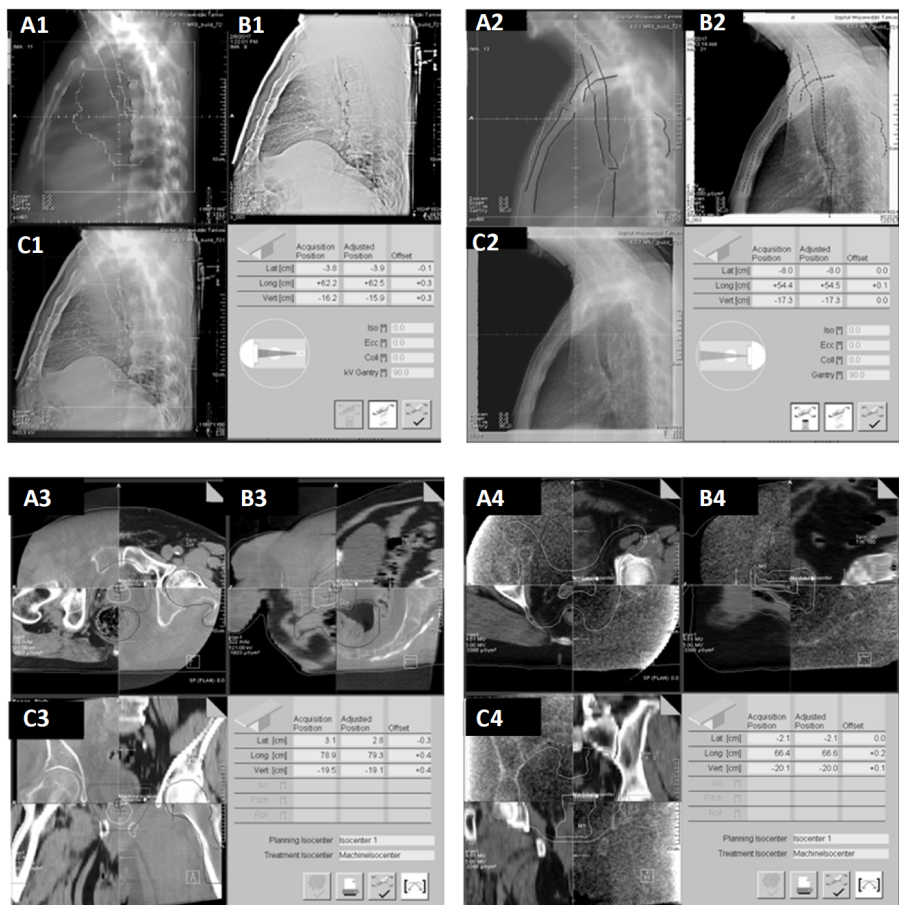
Portal images of a chest area (upper line) and CBCT of the pelvis area (lower line). Left-hand side images are performed with the kilovoltage radiation, right-hand side images with the megavoltage [Author's property].
